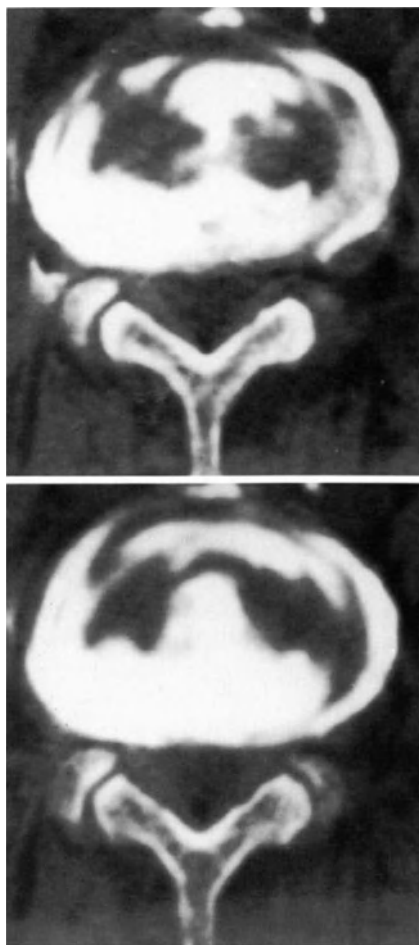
Disco-CT scans. Irregular opacification of the disc due to marked degenerative changes.
